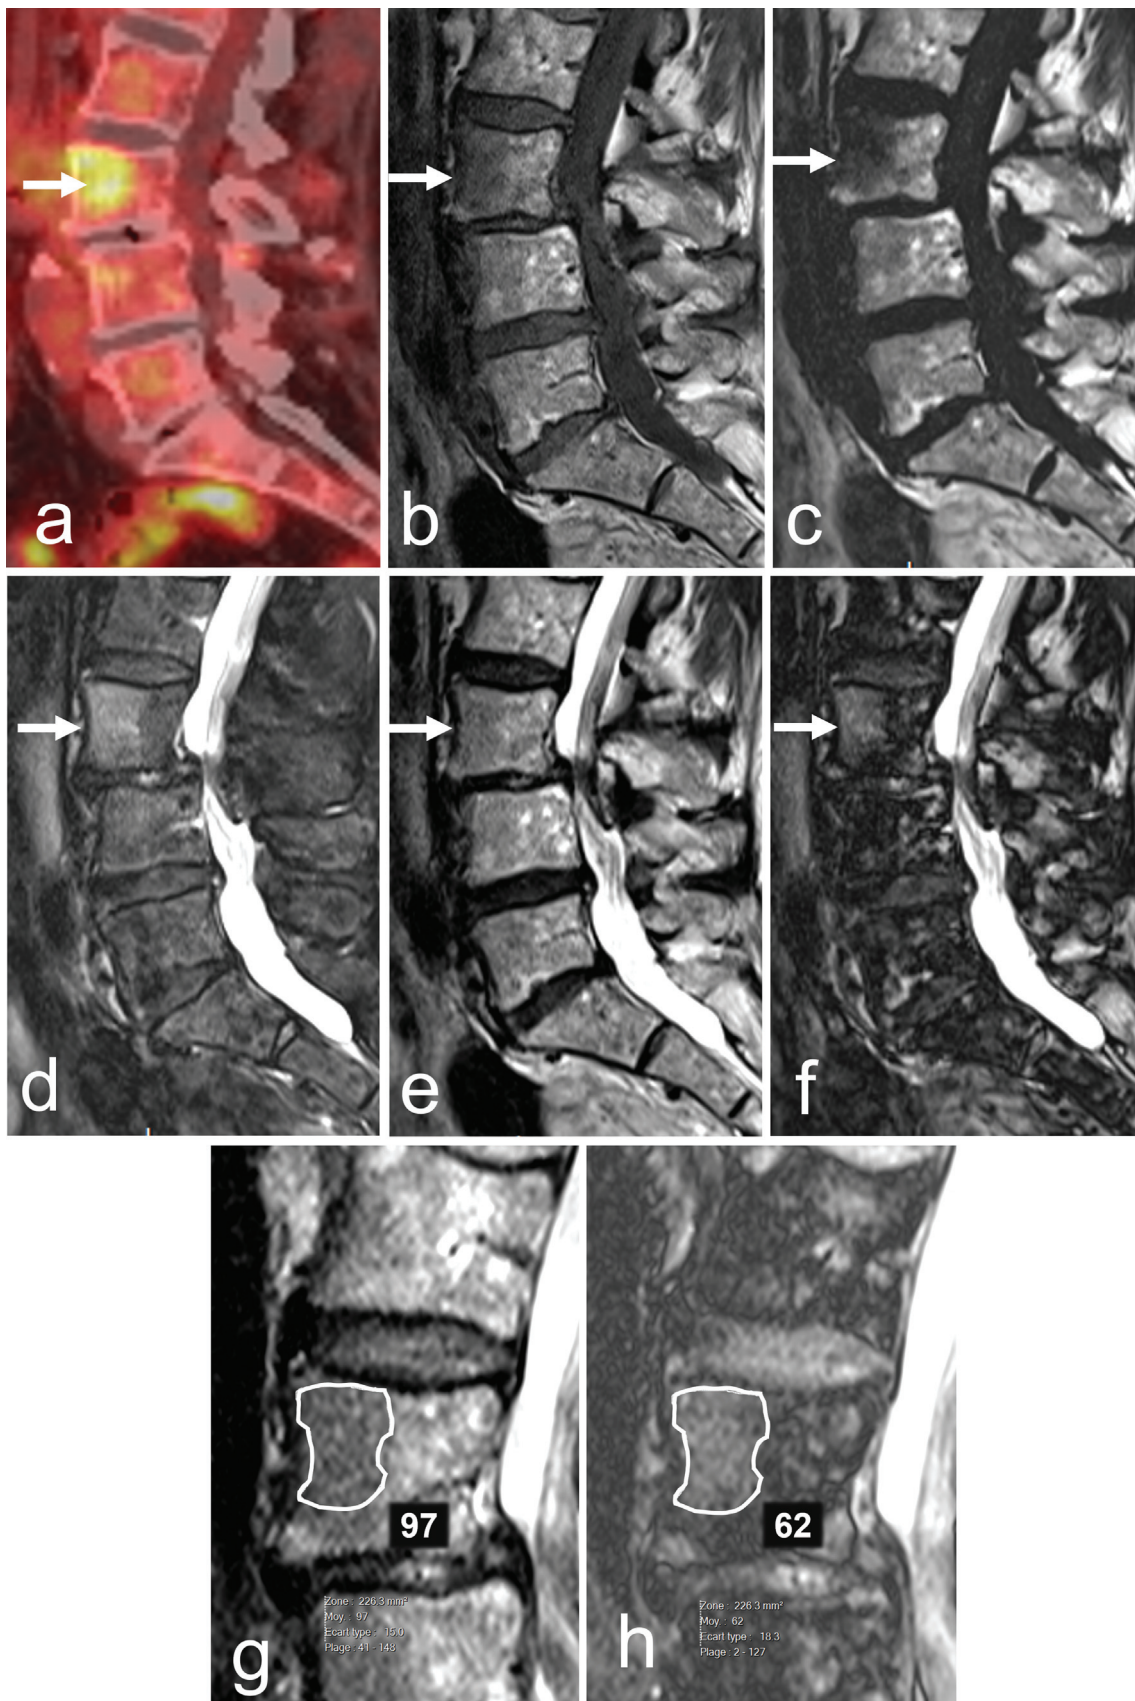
A 74-year-old woman with ovarian adenocarcinoma. (a) Sagittal reformat of fused fluorodeoxyglucose positron emission tomography/computed tomography images showing focal uptake in L3 vertebral body (arrow; maximum standardized uptake value = 6). Sagittal (b) T1-weighted, (c) fat-only, (d) water-only, (e, g) in-phase, and (f, h) out-of-phase T2-weighted Dixon images. The lesion (arrows) contains fat with a drop in signal intensity of 36%, suggestive of a non-marrow-replacing lesion. (g) Note the low signal intensity on the non-fat-suppressed image that concurs with benign nodular marrow hyperplasia. The lesion was unchanged on subsequent follow-up studies.
